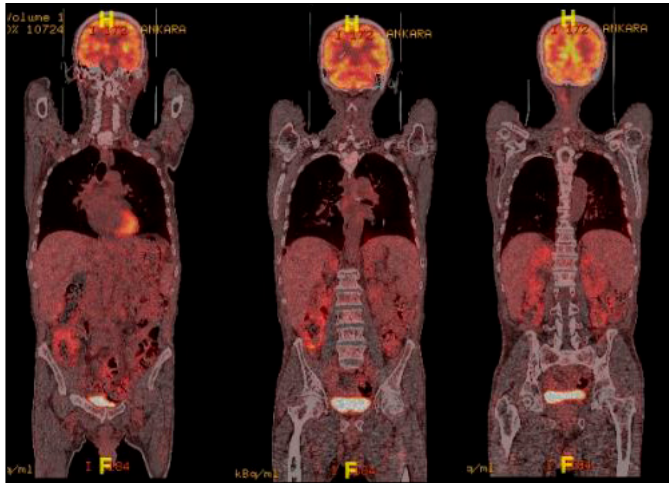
Antibiyoterapi sonrası FDG-PET/CT kontrol görüntülemesi
